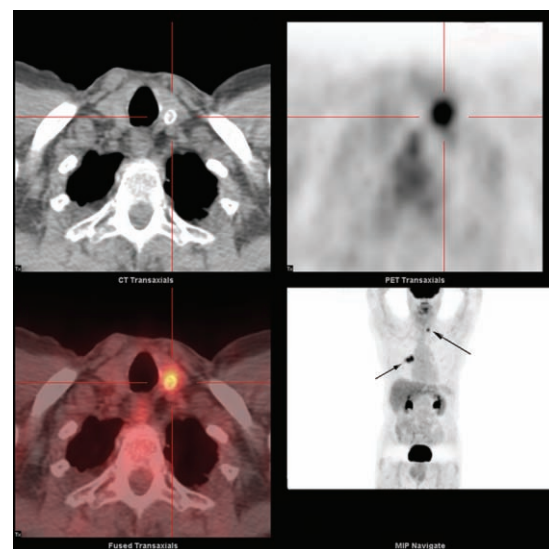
Half body PET-CT scan. The axial CT scan (top left), PET scan (top right), and fused PET-CT scan (bottom left) show abnormal focal uptake of ¹⁸fluorine fluorodeoxyglucose in the left lobe of the thyroid gland (indicated by red "crosshairs"). The maximum intensity projection of the PET scan (bottom right) shows abnormal focal uptake of ¹⁸fluorine fluorodeoxyglucose in the thyroid gland (long arrow) and two adjacent foci of abnormal ¹⁸fluorine fluorodeoxyglucose activity in the right lung in keeping with the primary lung carcinoma and an adjacent right hilar node (short arrow)
